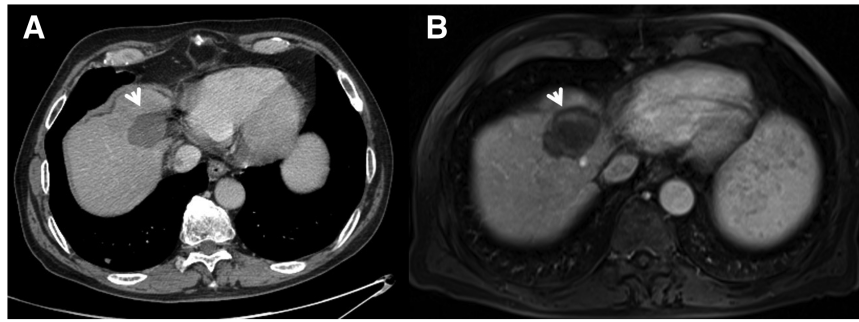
A 62-year-old man with hepatocellular carcinoma on VIII hepatic segment. Post-microwave ablation (MWA) treatment Multidetector CT scan [(A) arterial phase of contrast study] and magnetic resonance imaging study [(B) volume-interpolated breath-hold examination T1 weighted fat sat during arterial phase of contrast study]. The lesion shows no contrast enhancement, with hypodense (A) and hypointense signal compared with surrounding liver parenchymal (arrow).
